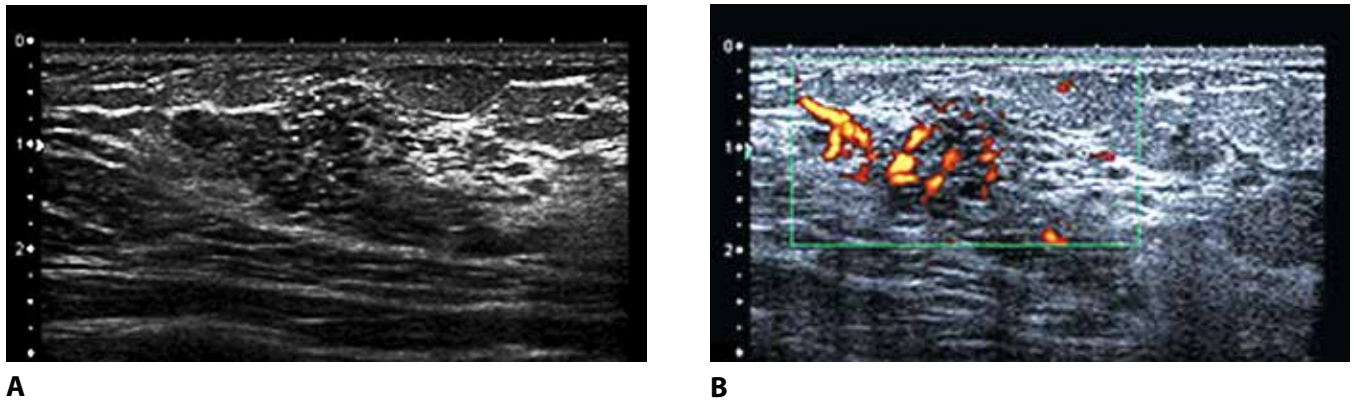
INTRADUCTAL CALCIFICATIONS. Echogenic flecks within tiny round dark areas are calcifications within ducts (*a*). Doppler US (*b*) shows vascularity within the region containing the dilated ducts and calcifications. Calcifications within ducts should be considered suspicious.
